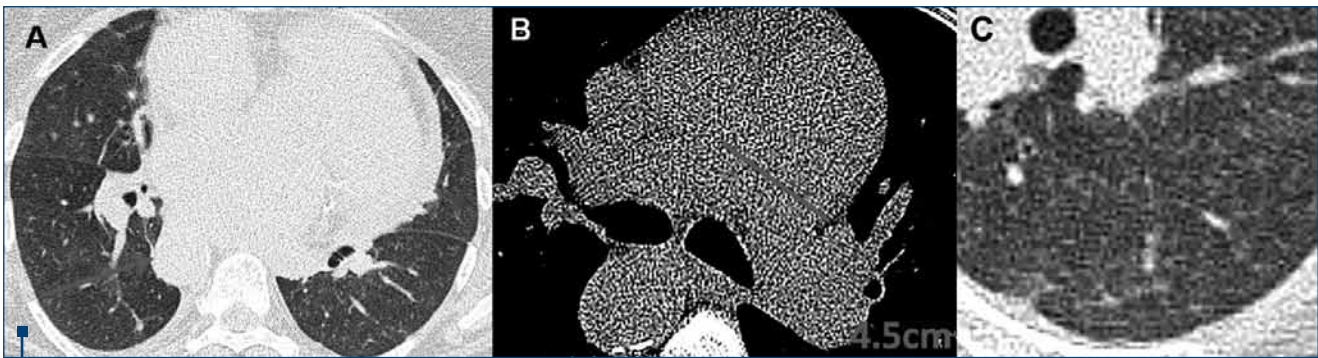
Computed tomography images A: lower lungs, transversal section showing ground glass interstitial infiltration, important cardiomegaly, right situated descending aorta; B: Great vessels transversal section showing pulmonary artery dilatation; C: Ground glass pattern in the lower left hemithorax
